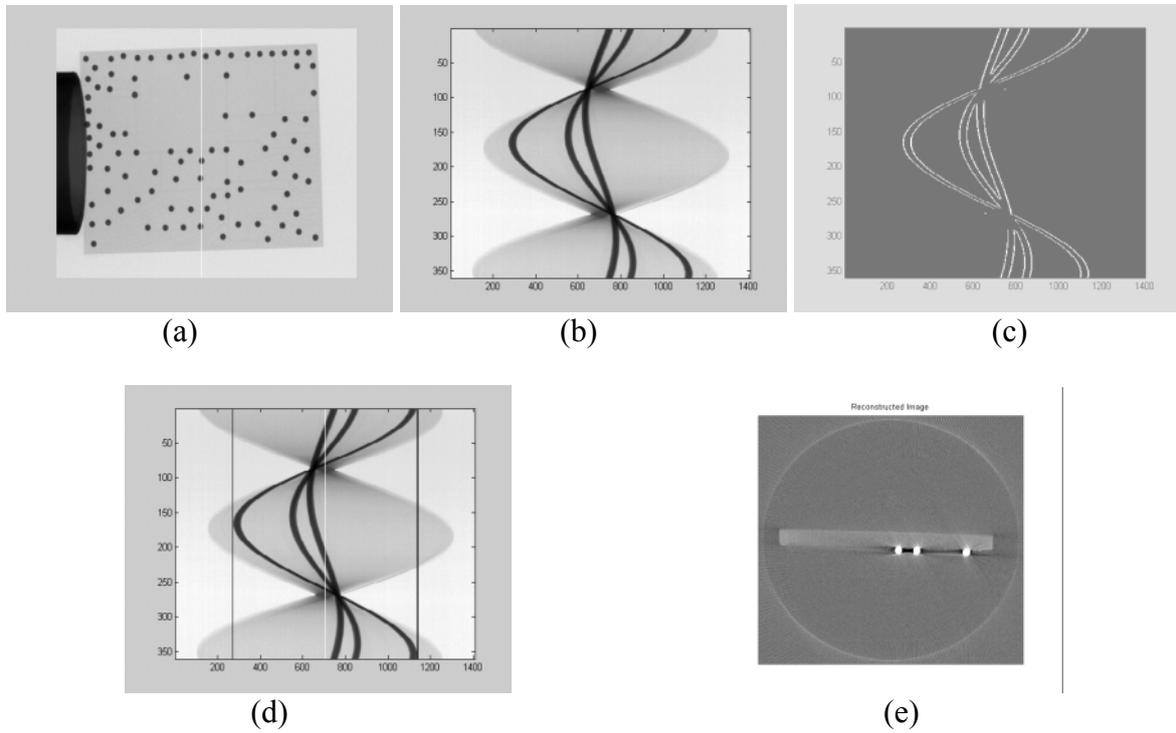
CT scan of a hearing-aid die: (a) A 2D projection; (b) the sinogram of one slice with the two boundaries (black lines) and central ray (white line) identified; (c) the reconstructed image of the slice in (b)
